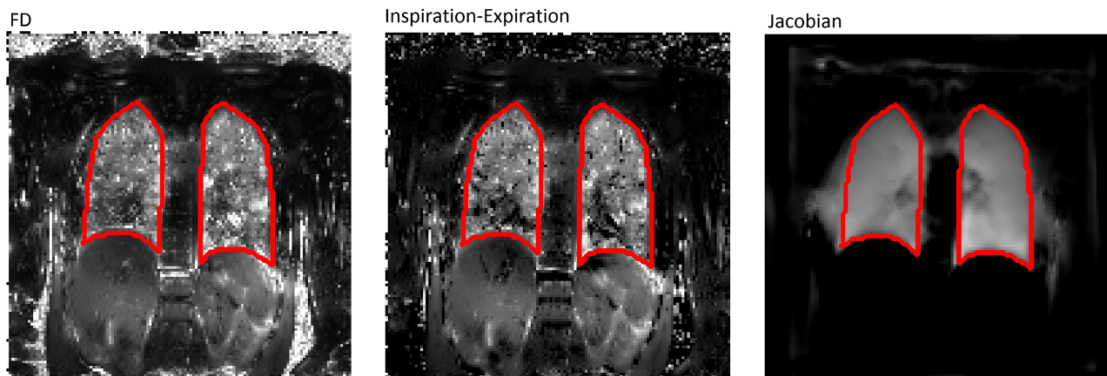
Mappings of the lung ventilatory function using dynamic MRI, extracted from Kjørstad *et al.*¹⁰⁷ Three fractional ventilation surrogates are inferred from 2D+t acquisitions in free-breathing: temporal Fourier decomposition to evaluate MR signal variations (left), intensity differences (middle) and the Jacobian of the deformation (right) between end-of-inspiration and end-of-expiration respiratory states. Intensity-based and deformation-based approaches result in different ventilation patterns, which could arise from the difference in smoothing, MR signal bias, or errors in the registration process.
